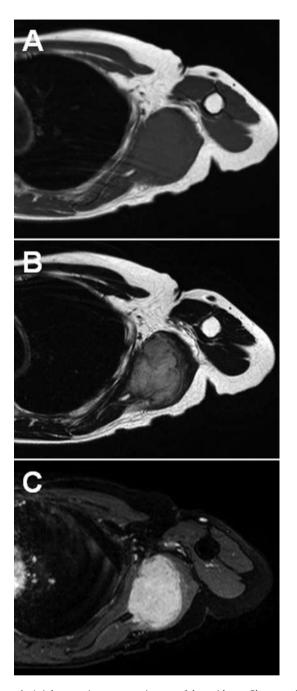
Axial magnetic resonance images of desmoid-type fibromatosis in the left axillary region. A: T1-Weighted sequence shows that the mass has intermediate signal intensity. B: T2-Weighted sequence shows that the mass has heterogenous high signal intensity. C: Contrast-enhanced fat-suppressed T1-weighted sequence shows intense and homogenous enhancement of the mass.
